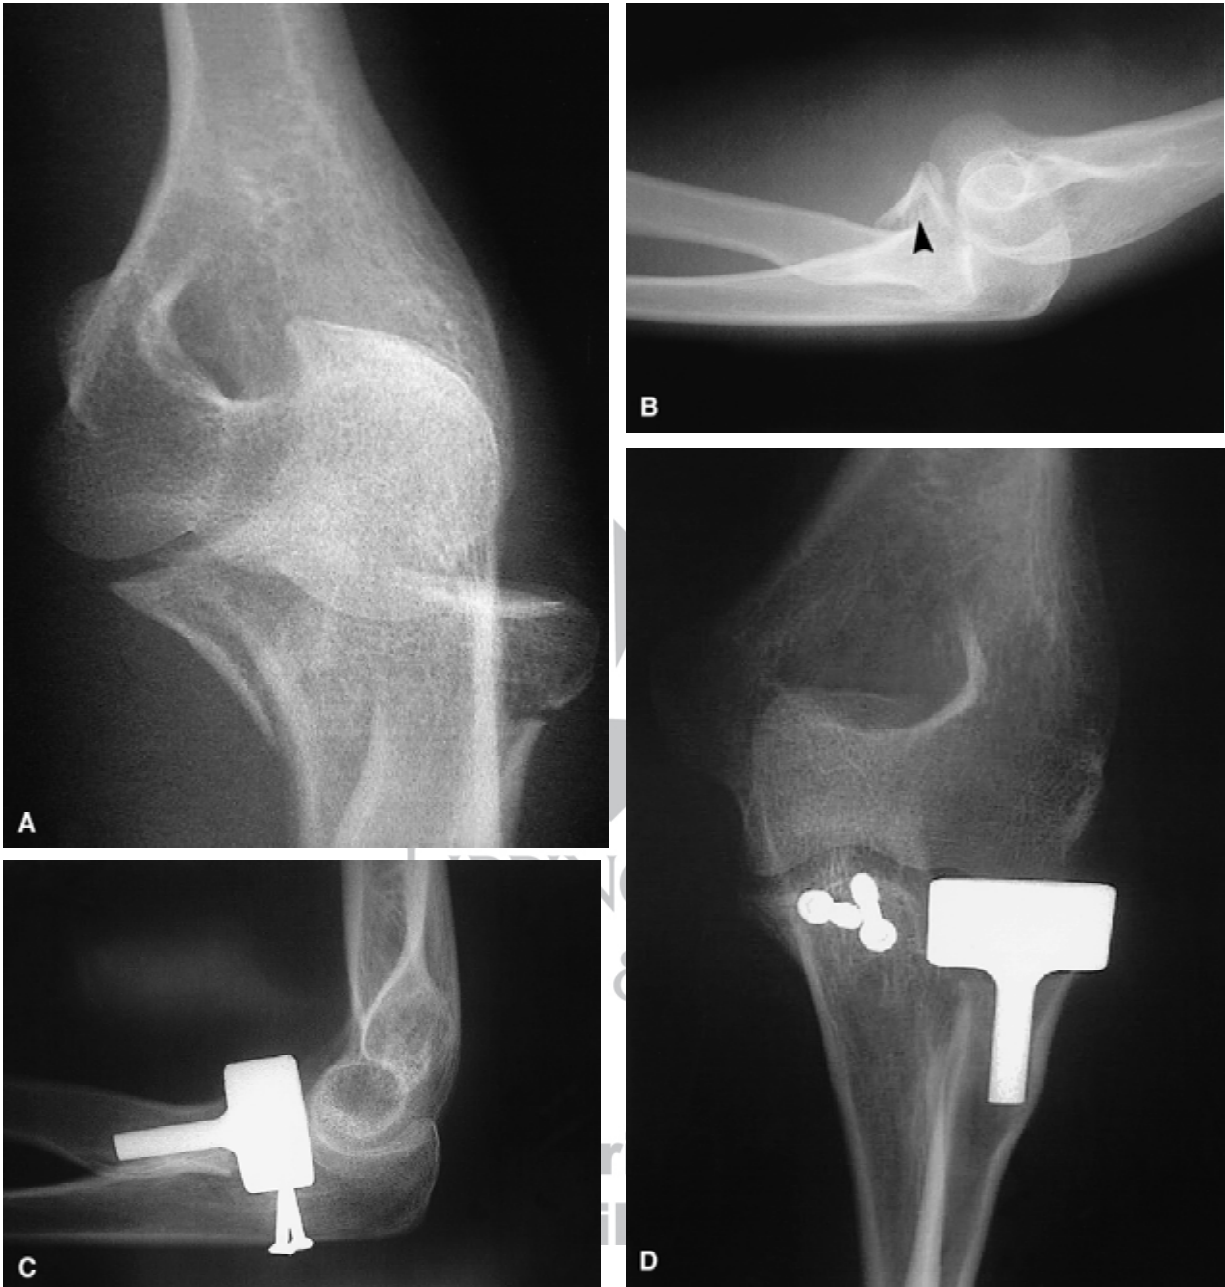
Anteroposterior (A) and lateral (B) radiographs of a young female patient with a partially reduced posterior elbow dislocation, radial head/neck fractures, and coronoid fracture (arrow). The operative repair consisted of coronoid fracture fixation with two cannulated screws inserted from the posterior surface of the ulna and, after failed attempts at fixation, metallic radial head replacement. The lateral collateral ligament complex was avulsed from the distal humerus and was repaired to bone. Early motion was instituted 9 days after surgery. Follow-up radiographs (C,D) reveal concentric reduction of the joint with coronoid union. The patient had a Mayo Elbow Performance score of 95 at 1 year.
